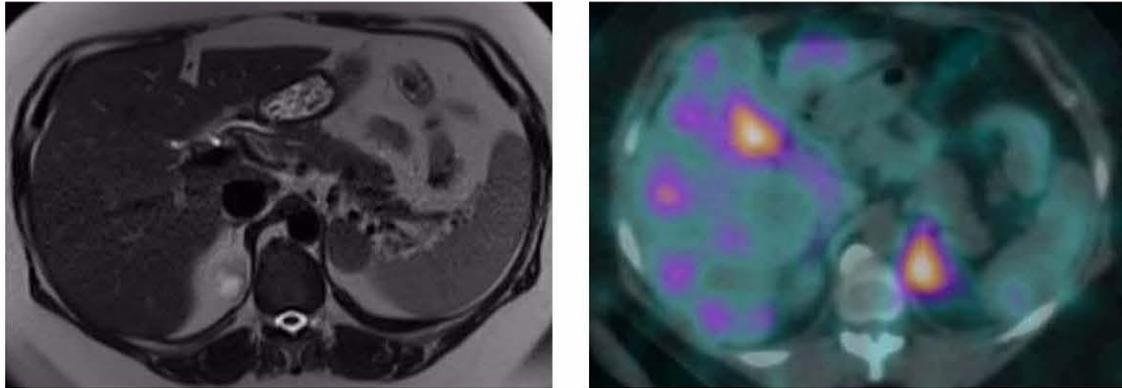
MRI Abdomen (left) demonstrating right adrenal adenoma 2.8 x 2.4 cm and left adrenal adenoma 3.4 x 2.7 cm; and 1b. Norcholesterol scan (right) demonstrating hyperfunctioning of left adrenal adenoma.
